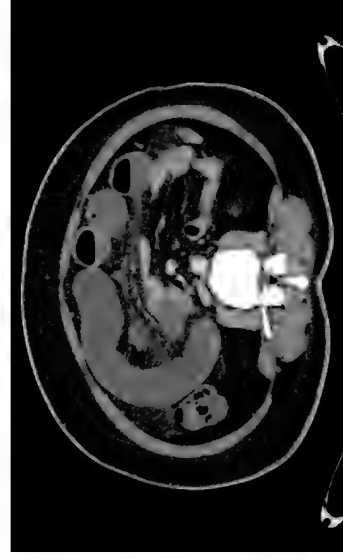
Axial CT scan through lower abdomen shows dilated loops of bowel.
